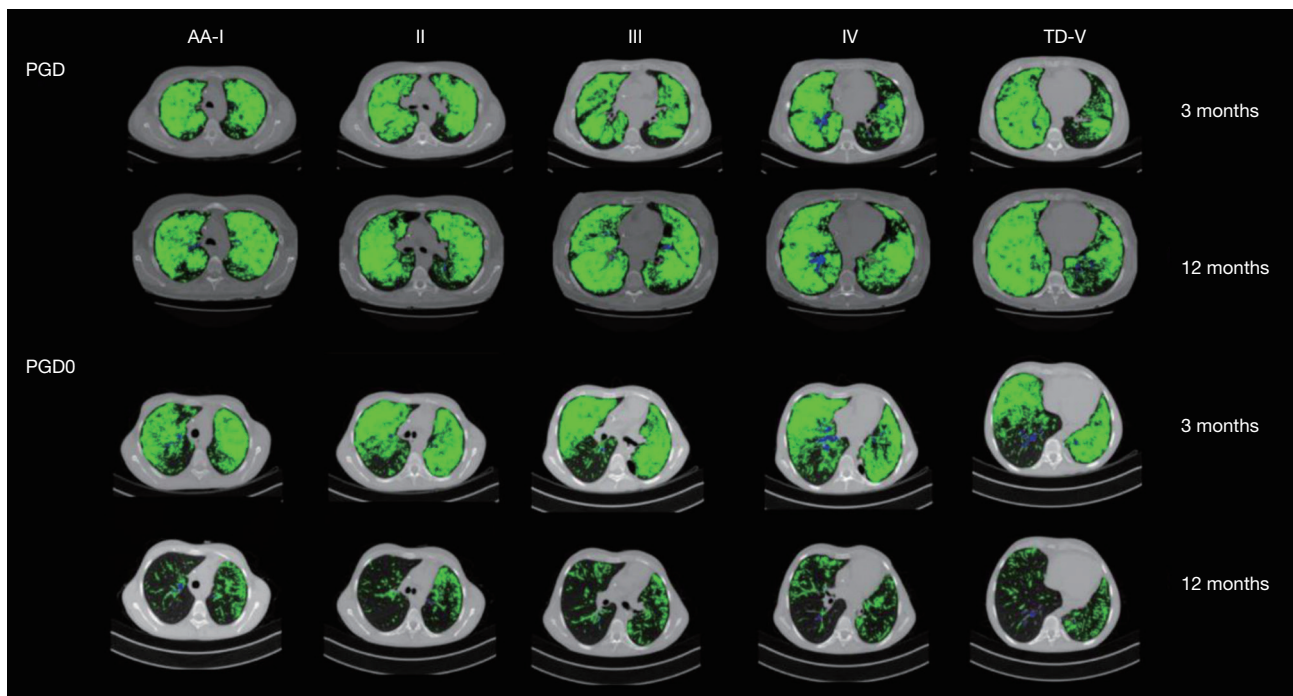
CT functional masks at 3 and 12 months from lung transplant of two representative PGD and PGD0 patients are shown at five equally-spaced lung levels from aortic arch (I-AA) to top diaphragm (VI-TD). Each pixel of the maps was classified as LV (green), C (blue), AT (red) and H (black). PGD, primary graft dysfunction; LV, low ventilation; AT, air trapping; H, healthy parenchyma.
